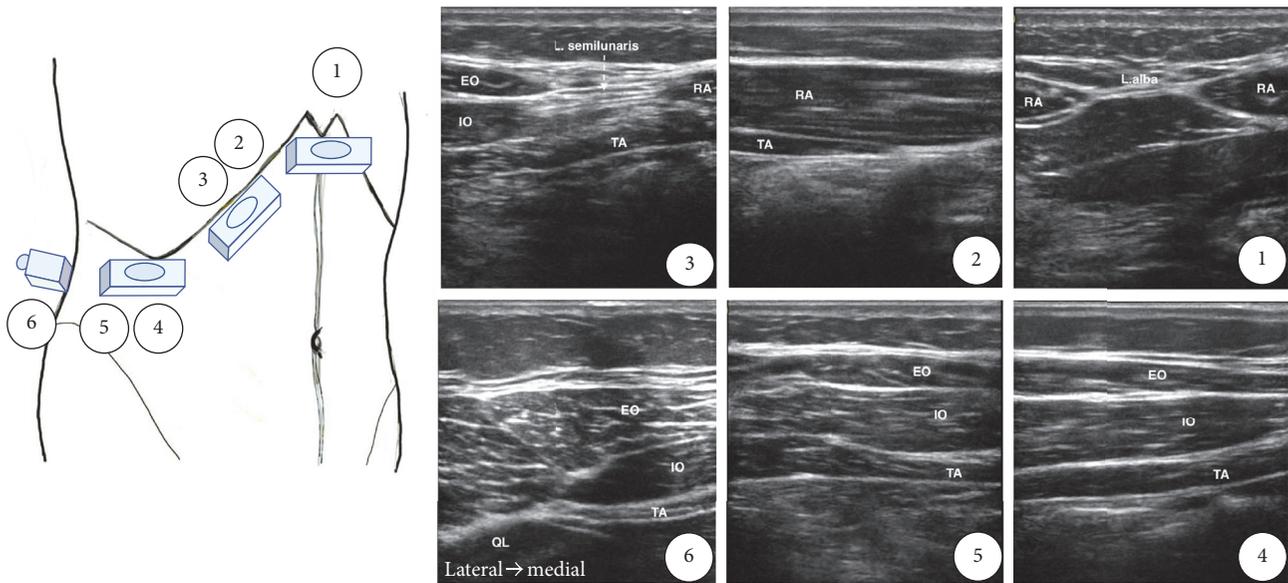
Ultrasound identification of the transversus abdominis plane. RA: rectus abdominis; TA: transversus abdominis; IO: internal oblique muscle; EO: external oblique muscle; QL: quadratus lumborum; L. alba: linea alba; L. semilunaris: linea semilunaris.
